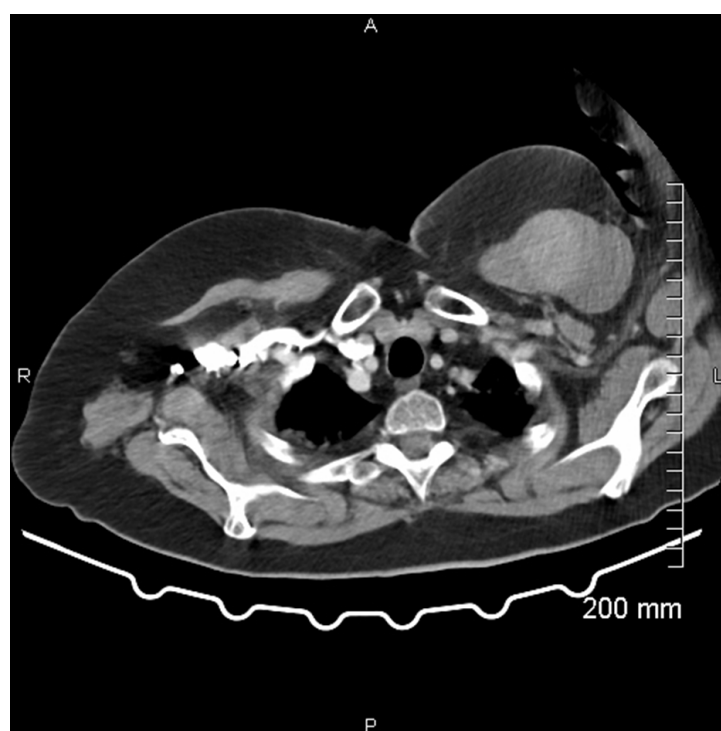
Axial image from the contrast enhanced portal venous phase CT of the thorax, abdomen and pelvis shows heterogenous expansion of the left pectoralis major muscle, measuring 7cm, consistent with intramuscular haematoma.
